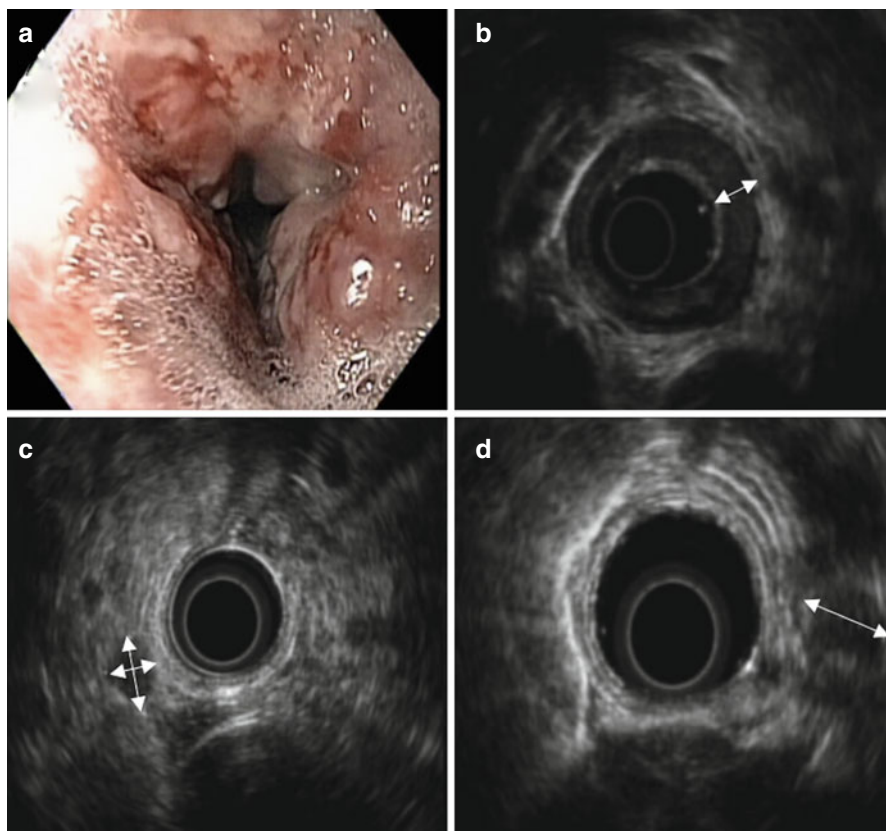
(a) Gastroscopic view of distal esophagus, circumferential Barrett's segment with severe nodularity. (b) Endoscopic ultrasound showing thickening of esophageal wall (*arrow*) staged as uT2. (c, d) Endoscopic ultrasound showing paraesophageal lymph nodes (*arrows*)
